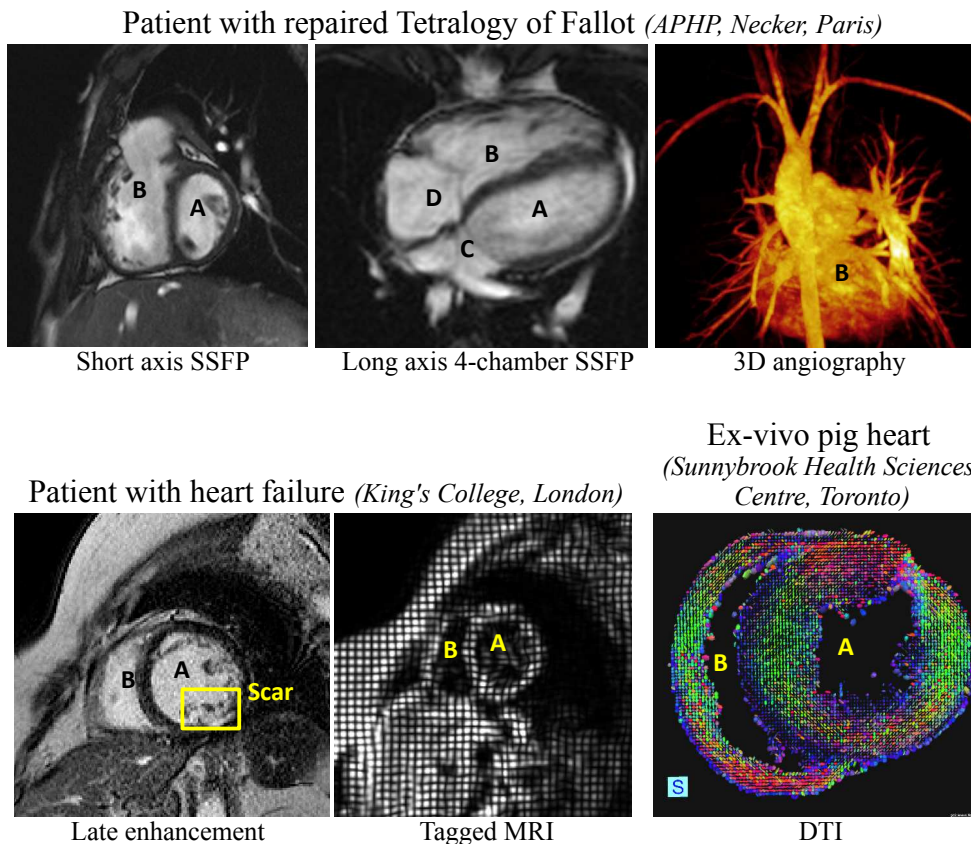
Example of MR images. A- Left ventricle, B- Right ventricle, C- Left atrium, D- Right atrium. Angiography colours are artificial to highlight the vessels. DTI colours encode fibre directions.
